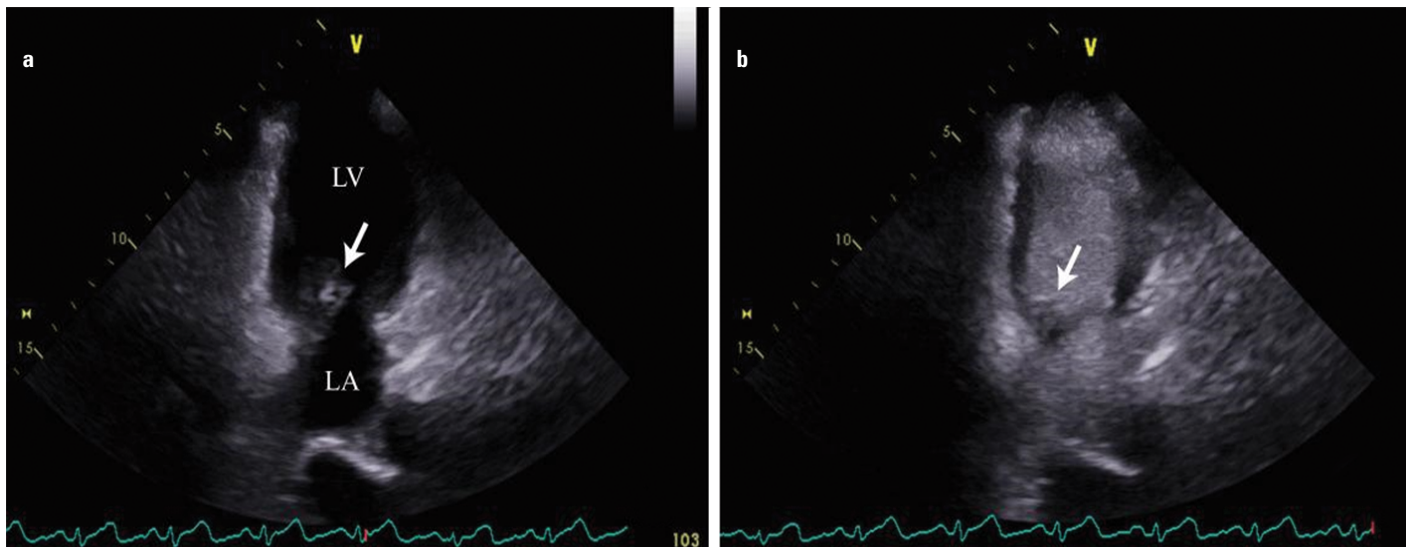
Intracardiac contrast echocardiography.
